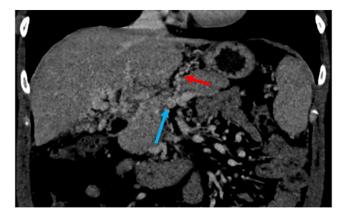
Pre–PVR-TIPS coronal CT demonstrates occlusion and cavernous transformation of the main portal vein (blue arrow), with upper abdominal collaterals including a prominent gastric varix (red arrow).
